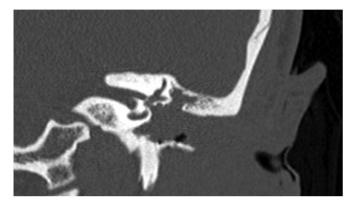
Left ear computed tomography scan, coronal section. Soft tissue occupies tympanic cavity. Ossicles and scutum are absent. Bone erosion of external auditoy canal can be noticed.
